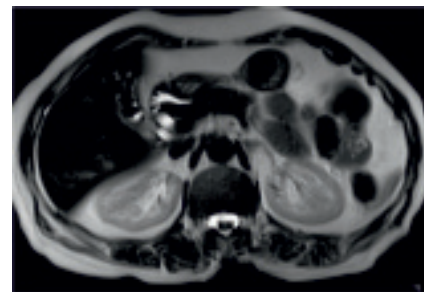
Axial T2W MRI shows dense pericholecystic adhesions near body & fundus with triple confluence. Patient was managed by open cholecystectomy.
